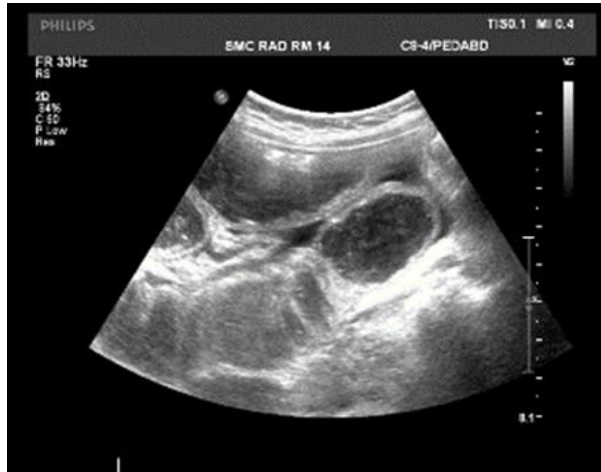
Ultrasound of the abdomen and pelvis, showing dilated bowel loops.
